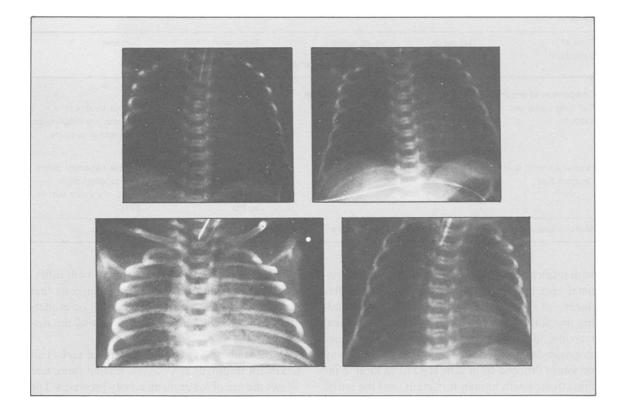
Chest radiographs obtained on twin infants delivered by caesarean section at 28 weeks' gestation. The upper 2 radiographs are at 1 and 16 hours after the birth of the first-born infant girl, weighing 1200g. The upper left panel, 1 hour after receiving human surfactant at birth, shows normal lung inflation, absence of reticulogranular pattern and a normal heart size. 16 hours after birth the lungs are essentially unchanged, with an enlarged heart compatible with a patent ductus arteriosus.
